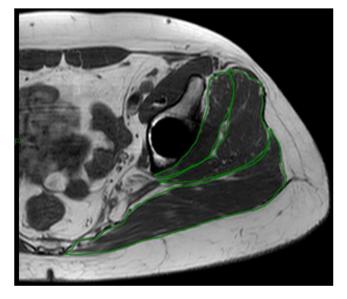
MRI muscle surface measurement of the gluteal muscles.
